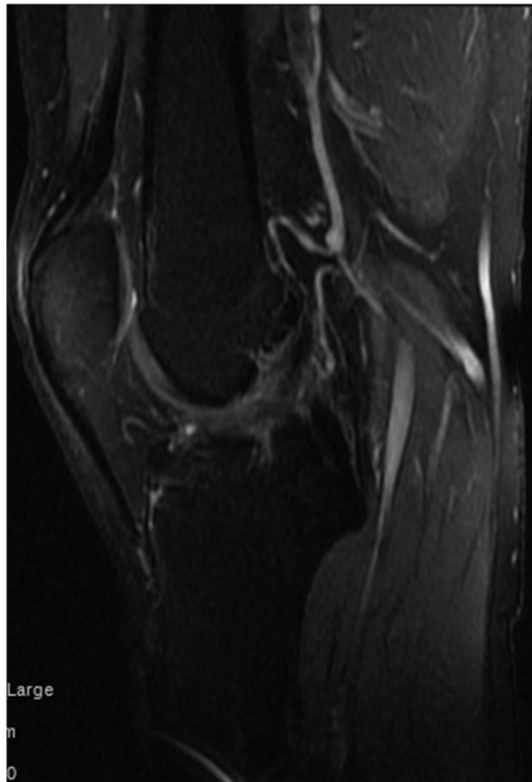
Partial tear image of a patient with a suspicion of a partial tear in the sagittal section in supine knee MRI with the knee in maximum flexion.
